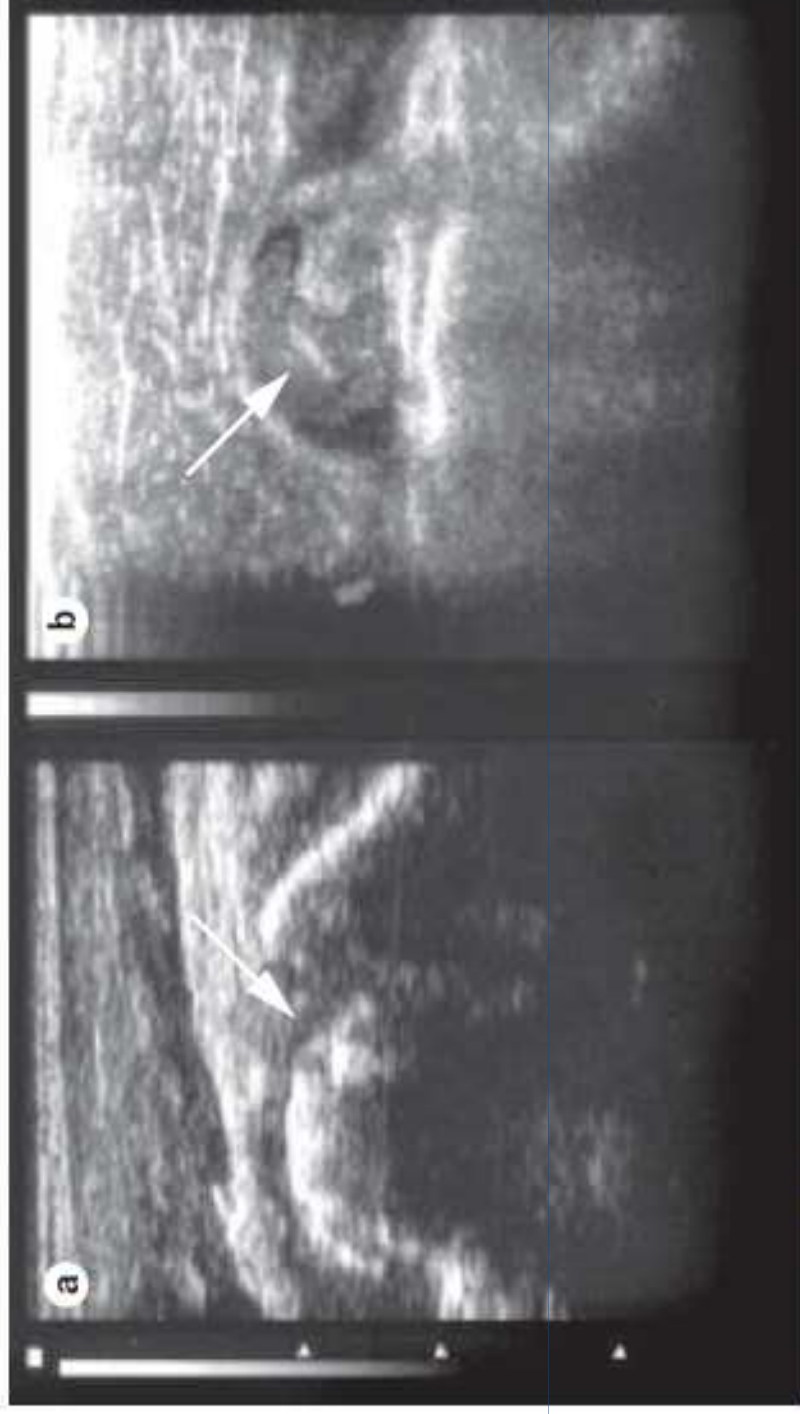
$A\beta_2M$ amyloid arthropathy of the shoulder and wrist in a patient undergoing long-term hemodialysis. a | In the shoulder, the biceps tendon is enlarged, with an inhomogeneous echo texture that indicates amyloidosis (arrow) without hypervascularization on power Doppler analysis. b | In the wrist, imaging reveals stretching of the joint capsule with solid and heterogeneous content and with cortical irregularity of the metacarpal bone (arrow).
